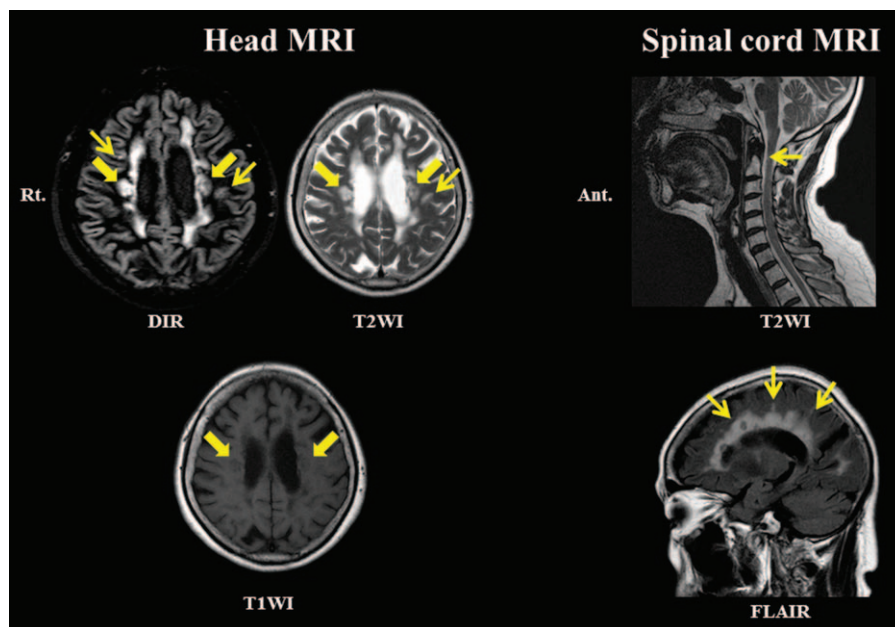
Head and spinal cord MRI on admission. Bilateral paraventricular (\Rightarrow) and juxtacortical (\rightarrow) focal demyelination on cranial double inversion recovery and T2-weighted MRI, T1 black hole (\Rightarrow) on T1-weighted MRI, and spinal cord (\rightarrow) demyelination on cervical T2-weighted MRI at high cervical levels were observed. Dawson fingers (\rightarrow) were also observed on the sagittal views. Ant=anterior, DIR=double inversion recovery, FLAIR=fluid attenuated inversion recovery, MRI=magnetic resonance imaging, Rt=right, T1WI=T1-weighted image, T2WI=T2-weighted image.
